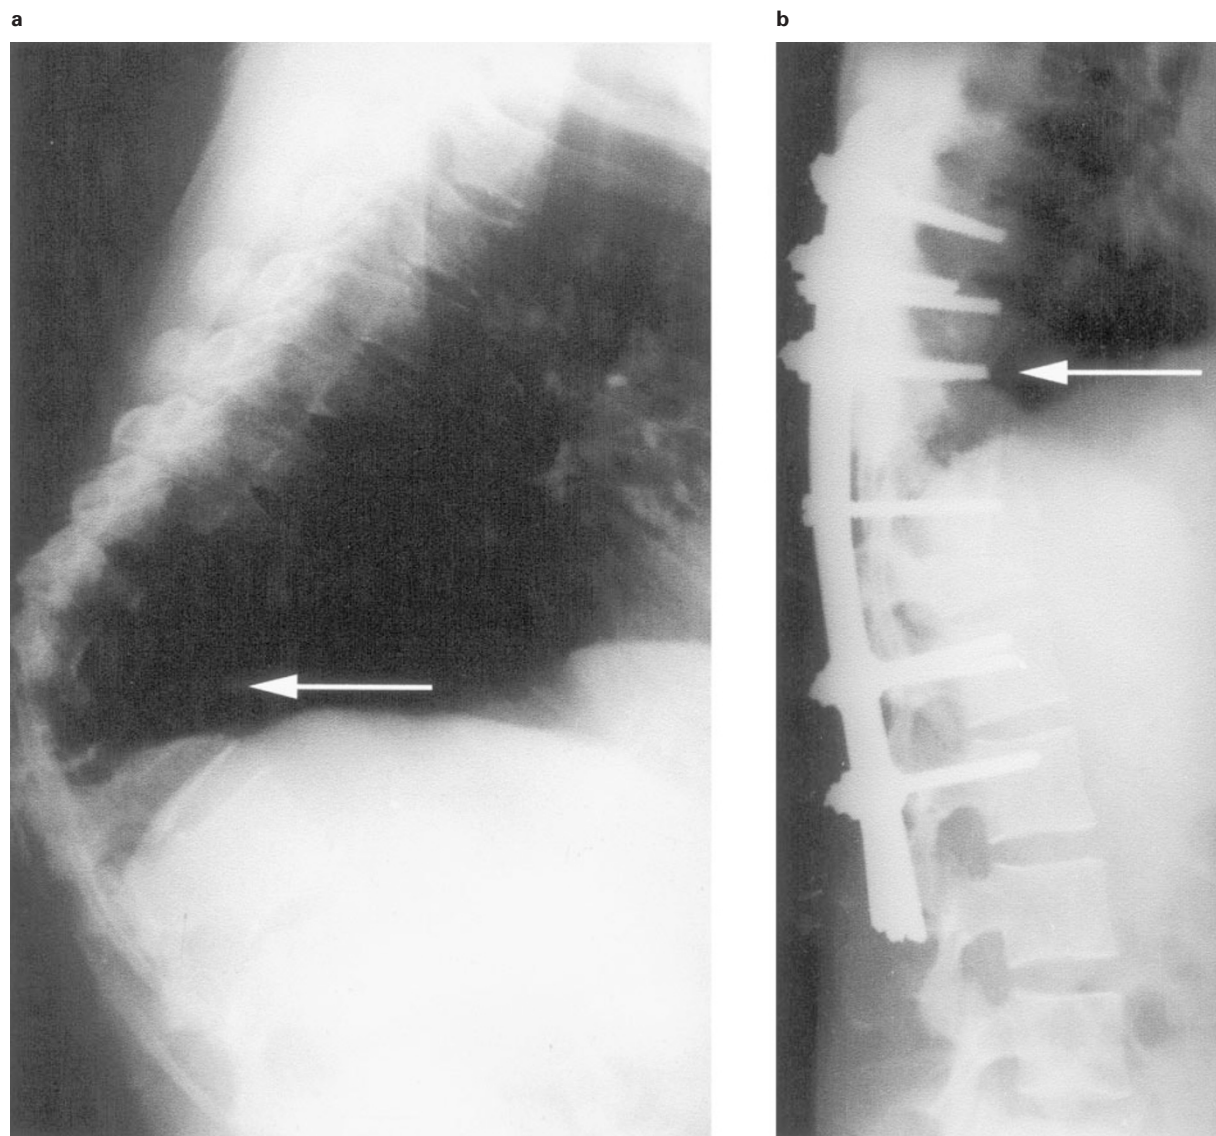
(a) Preoperative x-ray showing D11-12 tuberculous kyphosis with neurological deficit. (b) Postoperative X-ray showing kyphosis correction with fusion and segmental instrumentation using steffe pedicular plate fixation
